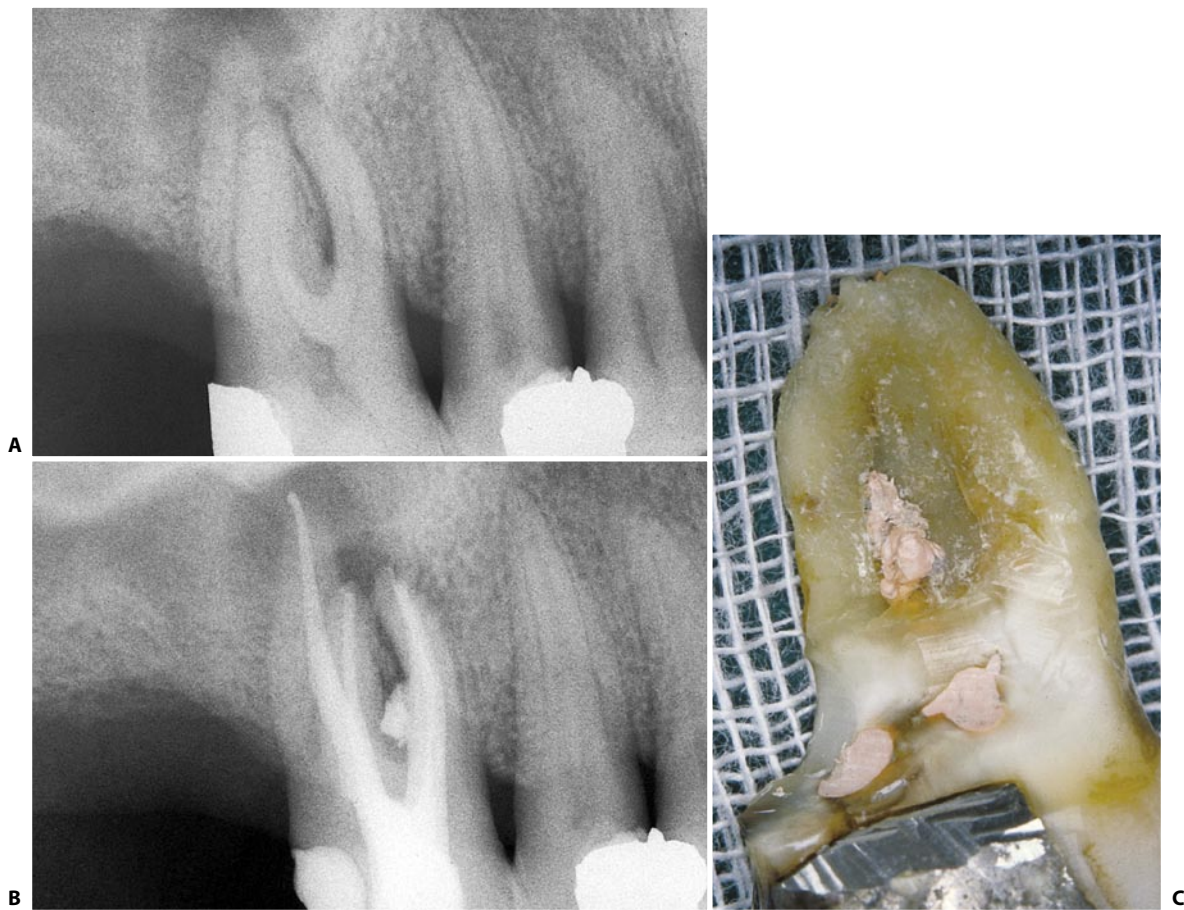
Stripping in the mesial root of the upper first molar. A. Preoperative radiograph: the mesial root reveals a slight distal curvature. B. Postoperative radiograph: at the moment of compaction of the gutta-percha, the too thin wall has fractured, causing the issuance of obturation material in the area of the bifurcation. C. The extracted root demonstrates the stripping that has occurred in the mesiopalatal canal (MB-2).
